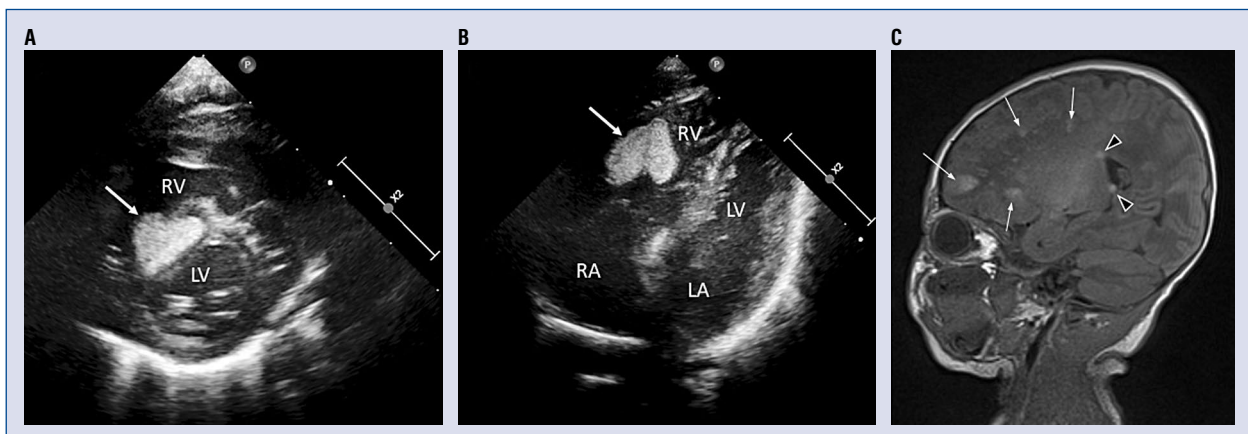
A, B. Transthoracic echocardiography of the patient; C. Brain magnetic resonance imaging of the patient. Arrows and arrow heads denote cortical tubers and subependymal nodules, respectively; LA — left atrium; LV — left ventricle; RA — right atrium; RV — right ventricle.
